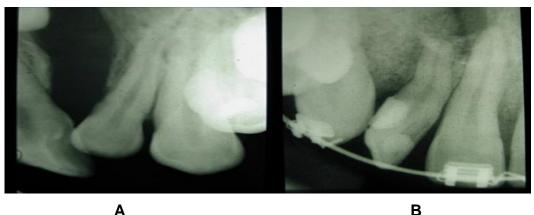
A. Dental X-ray showing the bone defect of the alveolar process of the upper jaw before surgery. B. X-ray taken 6 months after surgery. (No cavity, full bone formation and tooth eruption in place).
